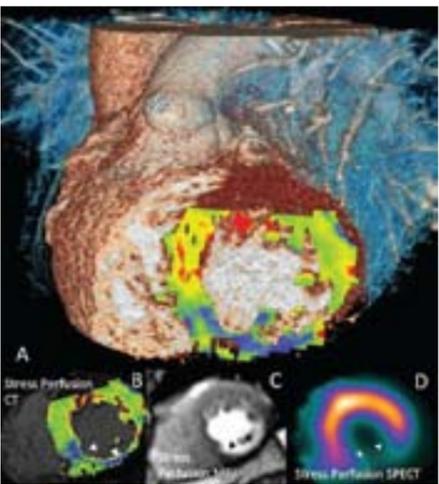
64-year-old man with past history of inferolateral myocardial infarction. Absolute myocardial blood flow (MBF) image shows a perfusion defect of the anterior and anterioseptal wall of the left myocardium. The perfusion defect was confirmed on perfusion MRI, delayed enhancement MRI (C) and on SPECT (D)
